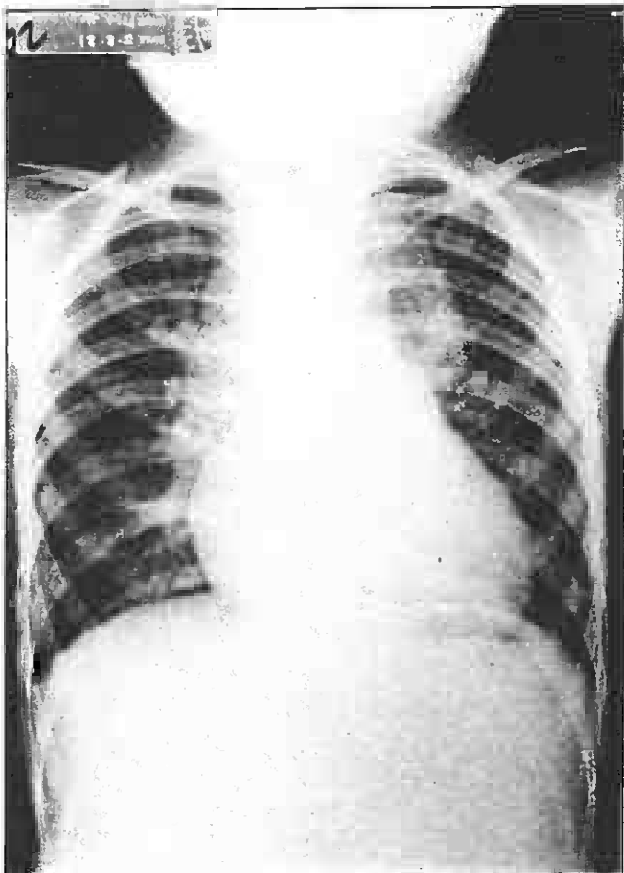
Chest roentgenogram showing classical snow-man appearance of total anomalous pulmonary venous drainage.
